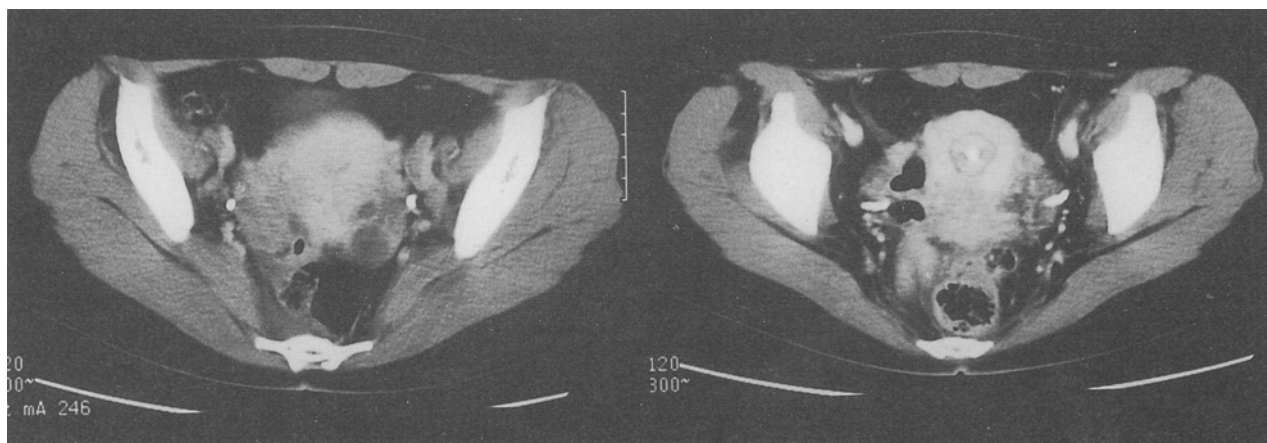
Computed tomography of the pelvis of the patient described in Fig. 1, taken before chemotherapy. A 6-cm cervical mass is detected, along with bilateral pelvic lymphadenopathy (left). After chemotherapy, the cervix is remarkably decreased in size, and bilateral pelvic lymphadenopathy has disappeared (right).
